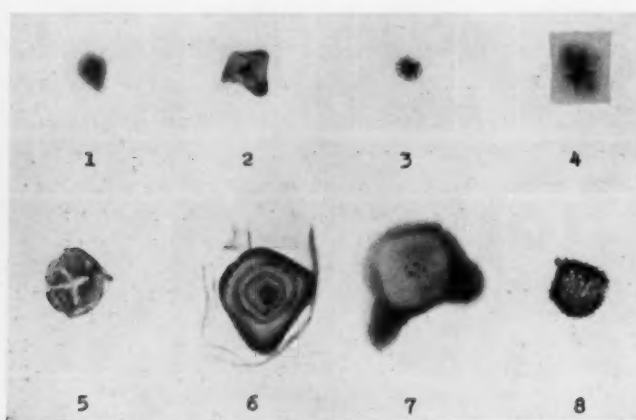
Roentgenogram of stones removed from different gallbladders showing different arrangements of radiopaque calcium carbonate shadows.
